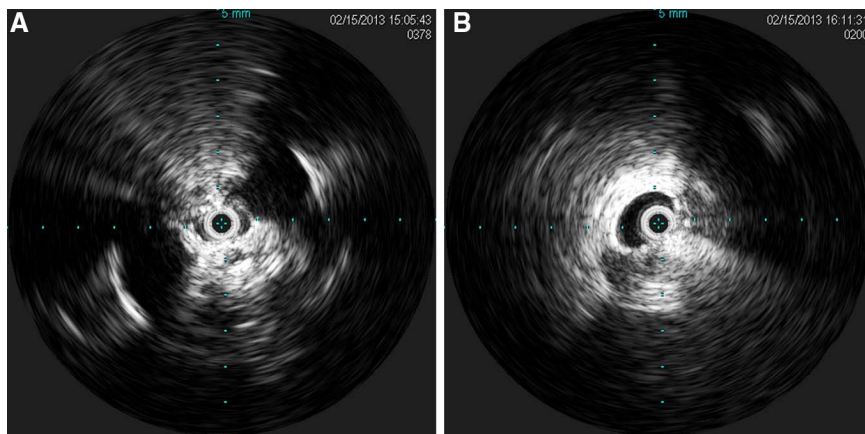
A, Intravascular ultrasound of compressed left common iliac vein with minimal lumen diameter. B, After angioplasty and stent of the left common iliac vein, there is significant improvement of the lumen. The hyperechoic Doppler spectra in both images is indicative of severe chronic fibrosis of the vein wall.
